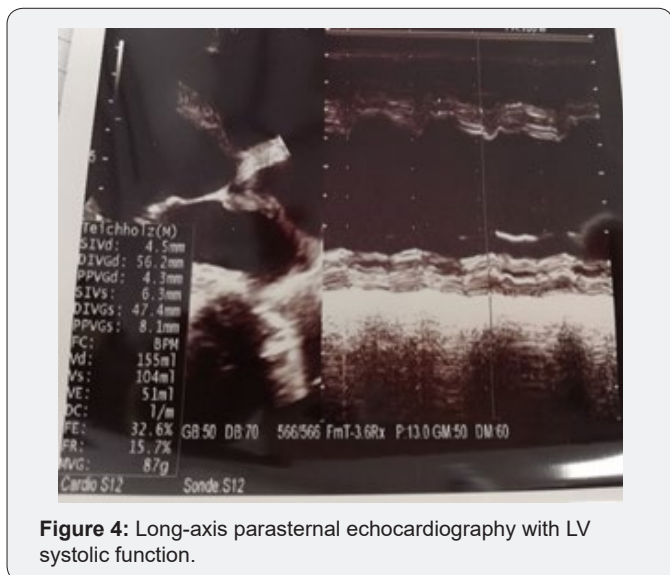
Long-axis parasternal echocardiography with LV systolic function.
